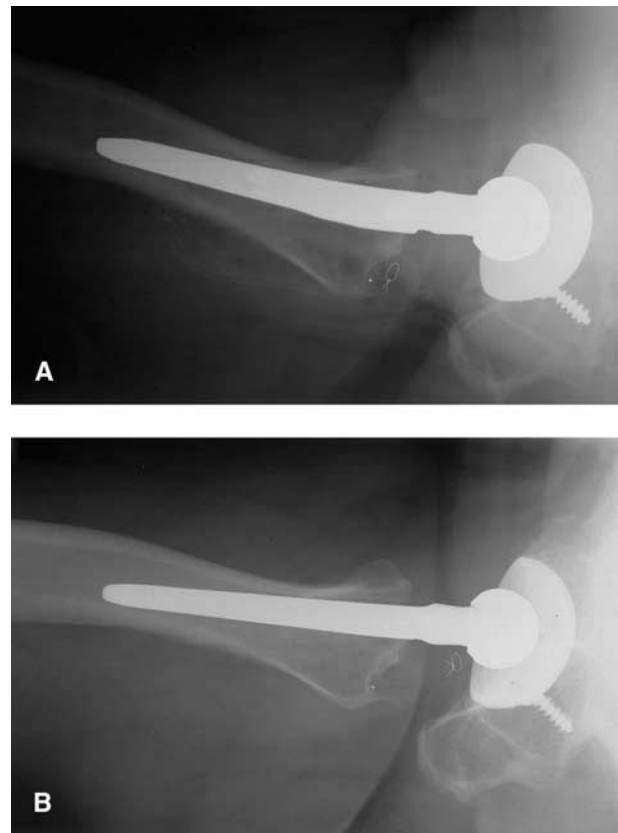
Late failure of piriformis muscle repair. Reference points are close to each other in the radiograph obtained on the first postoperative day (A) but >2.5 cm apart in the radiograph obtained 3 months postoperatively (B).
